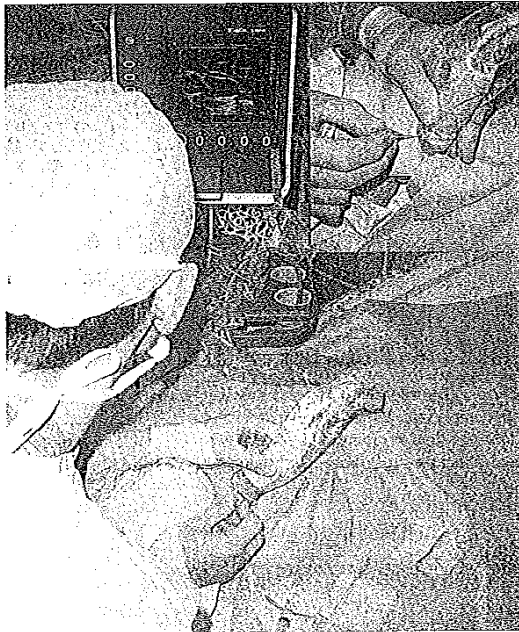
The operator, the child, and the ultrasound machine are positioned such that they form a single line of sight. This allows the operator to look easily from the screen to the insertion site. It also leads to a more logical and intuitive orientation of the ultrasound image, such that objects on the left of the field appear on the left (as seen by the operator) of the screen. The inset shows the detail of how the probe and needle are held. The needle is held in the dominant hand. The position should be comfortable. The ulnar border of the scanning hand should rest gently on the patient (to steady it) and the needle and probe are held in a pencil grip. This allows for fine movements of the probe and needle. The needle is held at a steep angle and the probe angled towards the needle to maximize visibility. There is no need to aspirate on the syringe while advancing the needle, if the tip is continually visualized.
